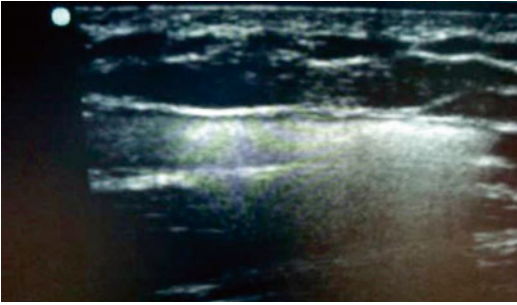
Tracking of foam sclerosant with ultrasound
